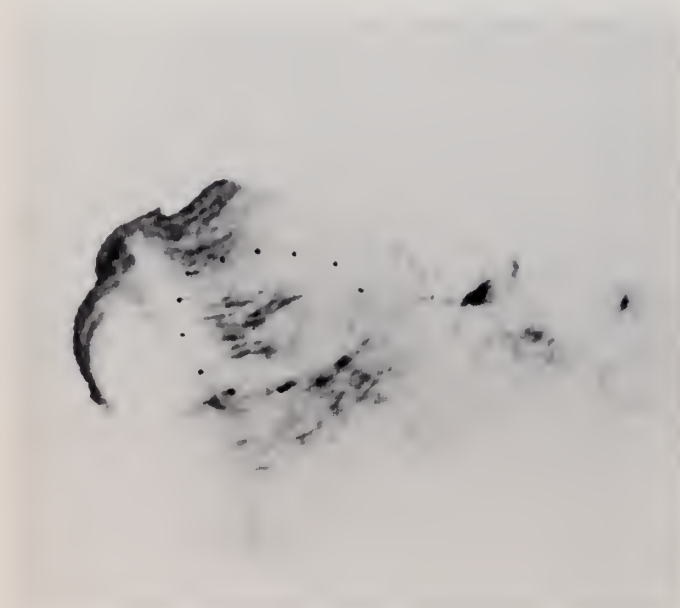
Sonography right kidney, transverse section.
